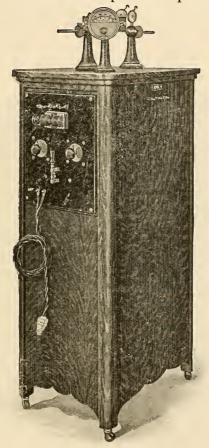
Combination apparatus delivering X-ray, High Frequency, Auto-condensation and Diathermy.
